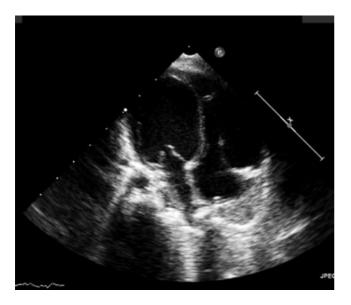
Ultrasound image of the infant at 5 months of age, showing the still-globular appearance of the left ventricle. The end-diastolic dimensions were at the upper limits of normality, and remained so at 17 months of age.
